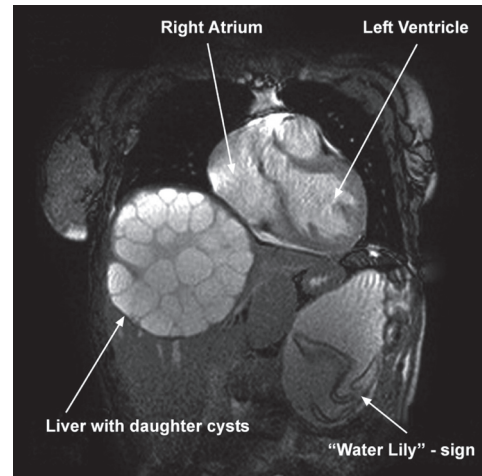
T2-weighted magnetic resonance study of the torso (coronal view) demonstrates the presence of hydatid cysts in the liver and the lesser peritoneal sac ('water lily' sign).
